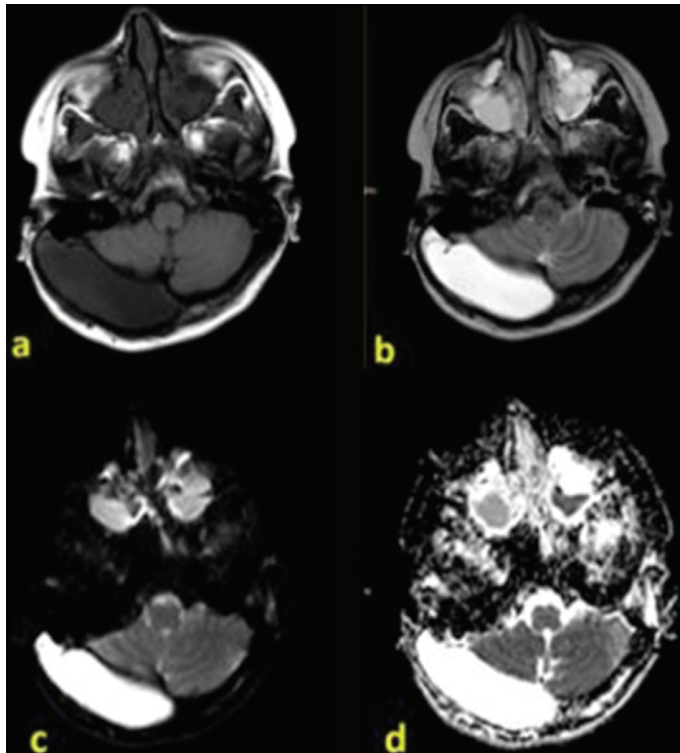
Cranial MR shows that the cystic lesion on right occipital region, has the same signal intensities as CSF with T1(a) and T2 (b) weighted images but there is not diffusion restriction on DWI (c) and ADC (d) sequences
